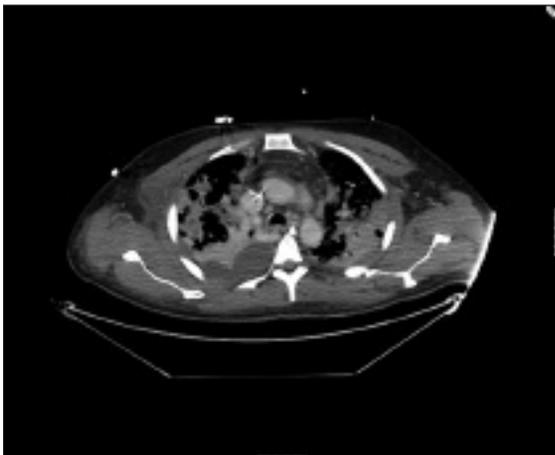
Chest CT scans during ICU stay: extensive bilateral pleural effusions diffuse bilateral alveolar infiltrates and nodular opacities with cavity forming consistent with necrotizing pneumonia.
